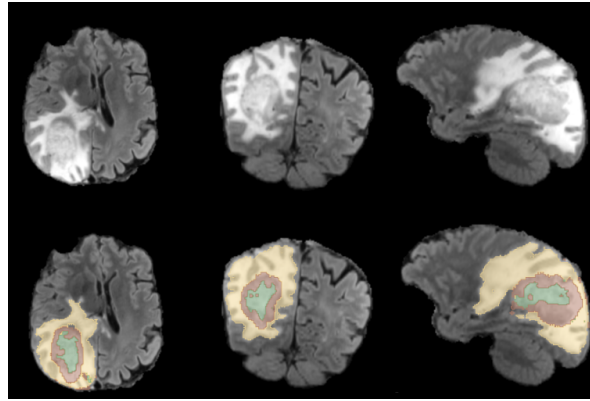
Multi-channel training pathway submission FLAIR example.
